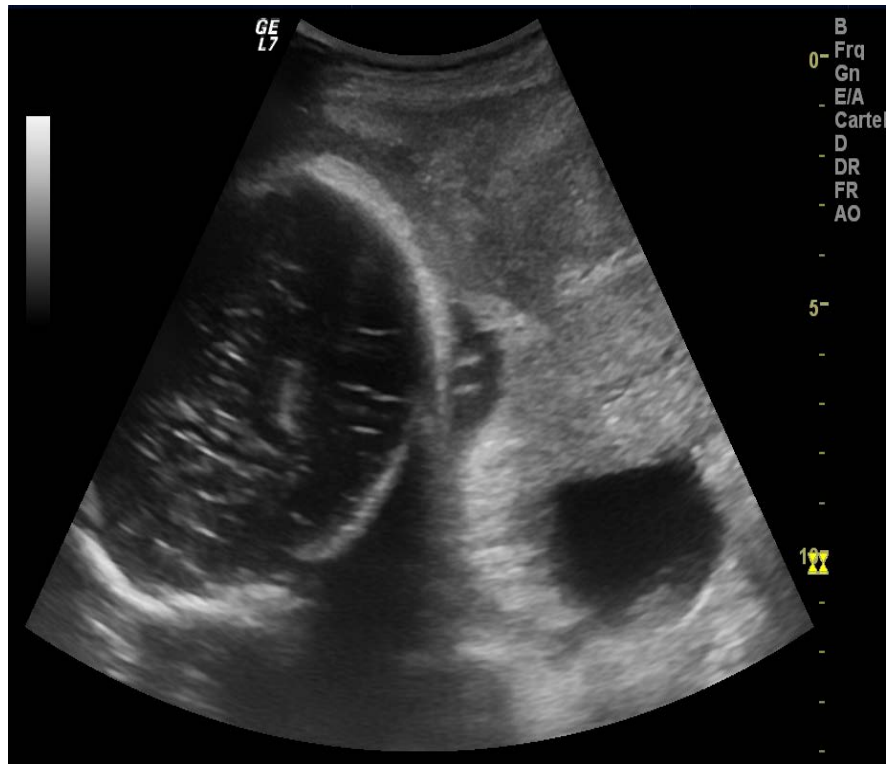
Axial ultrasound scan showing right lateral uterine rupture (white arrow).
